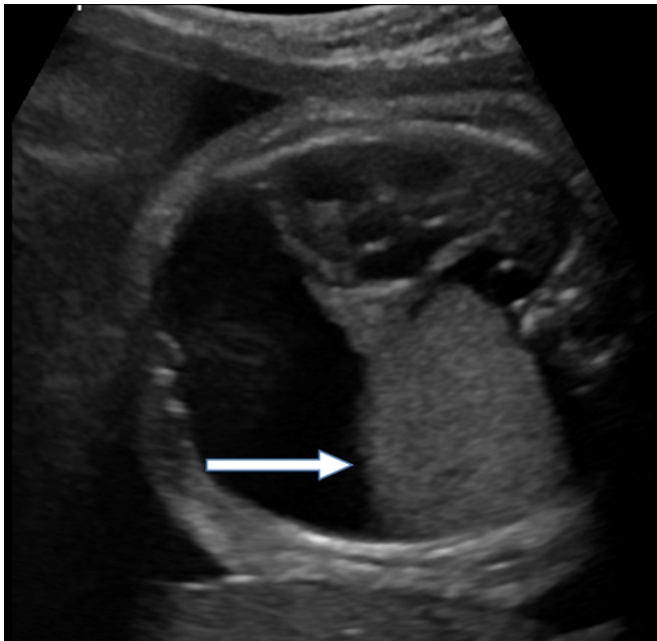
Ultrasound showing a solid well-defined echogenic mass with underlying collapse and associated pleural effusion with resultant shift of mediastinum and heart towards right side.
